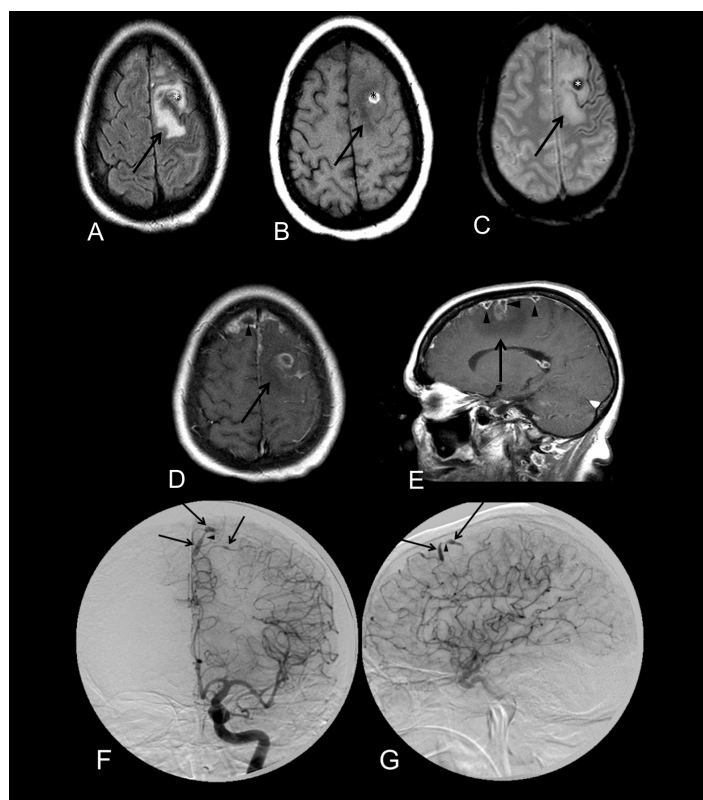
A-E: Brain MRI: axial images in sequences of FLAIR (A), T1-weighted (B), T2-weighted (C), T1-weighted post contrast (D), and sagittal T1-weighted post contrast (E). Lesion with vasogenic edema in frontal superior gyrus and pre-central gyrus of the left frontal lobe (arrows) with a hemorrhagic spot (\*).
